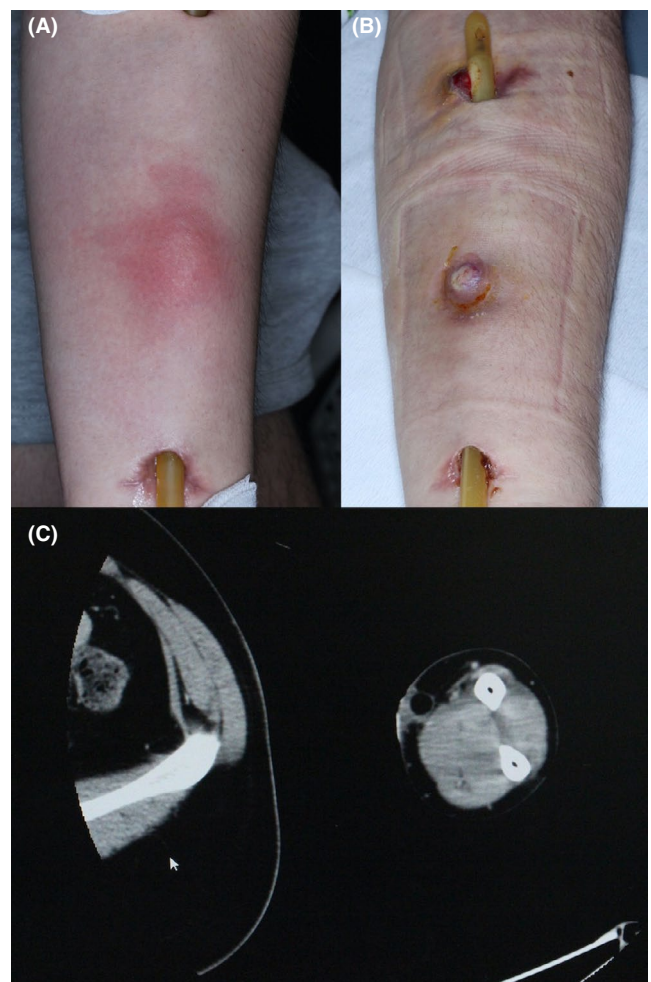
(A) Clinical findings of initial visit: a dark reddish erythematous lesion on flexor aspect of left forearm. (B) Recurred swelling two weeks after initial visit. (C) Subcutaneous abscess was visualized on computed tomography
